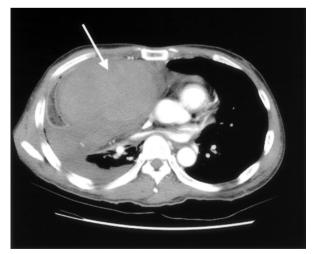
Thoracic CT scan revealing a huge, dense, well-defined mass (70 x 106 mm) (white arrow) near the interposed colon in the right hemithorax, with compression of the interposed colon and right lung.
